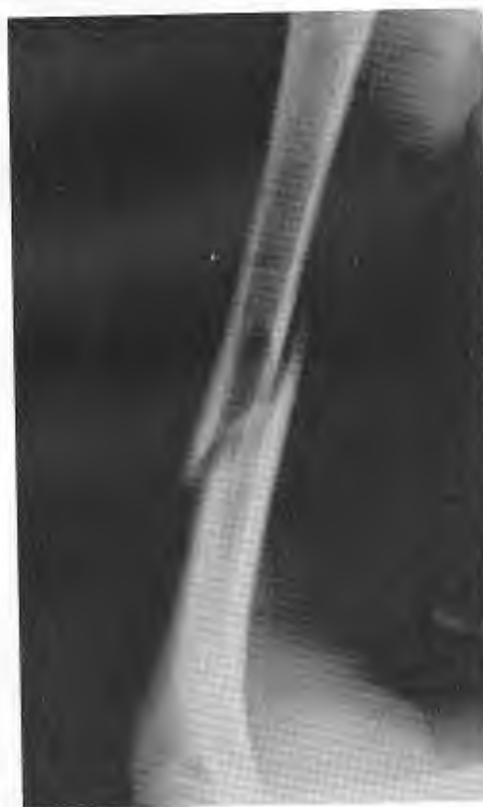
Lateral radiograph shows humerus fracture in outfielder who had no previous complaints, as he was throwing the ball toward the plate, he had felt acute pain. This healed uneventfully in a hanging arm cast for 6 weeks.
